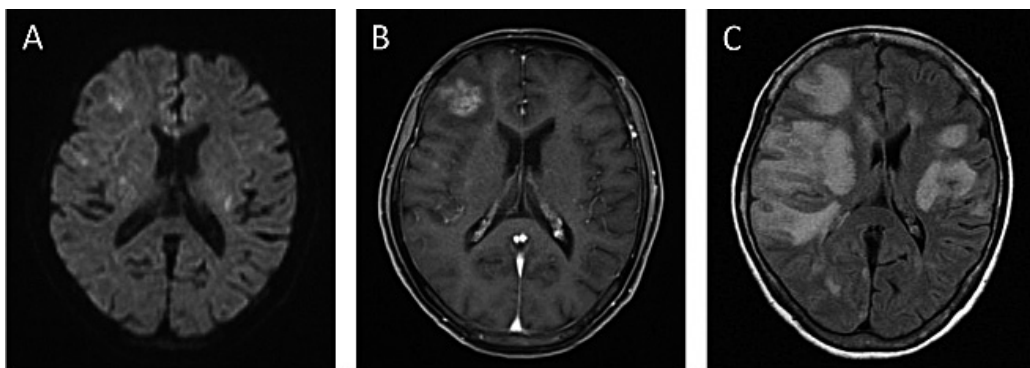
(A) Diffusion weighted magnetic resonance (MR) image at disease onset showing multiple high intensity lesions in both cerebral hemispheres. (B) Gadolinium-enhanced T1 weighted MR image at disease onset showing the lesions with contrast enhancement mainly in the right frontal lobe. (C) Fluid-attenuated inversion recovery MR image performed 6 weeks after onset demonstrating multiple high intensity areas progressing in both cerebral hemispheres.
